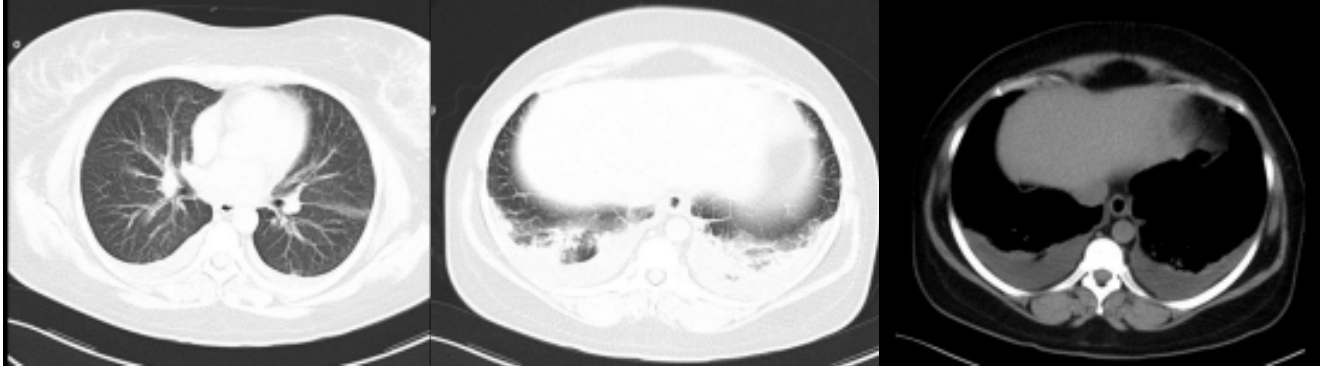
Preoperative pulmonary CTA
